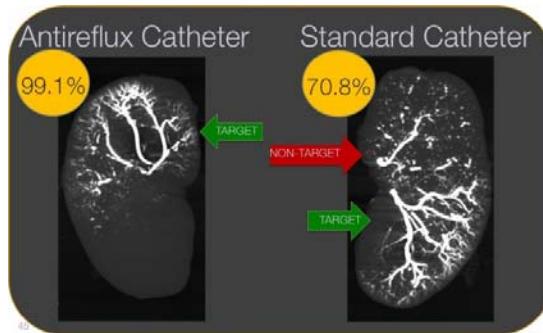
Comparison of the Surefire Catheter to a commercially available infusion catheter. CBCT was performed on explanted kidneys after embolization. Left: The Surefire catheter achieved 99.6% infusion efficiency. Right: The commercially available catheter achieved 68.2% infusion efficiency, with over 30% of the dose being delivered to non-target tissue.
